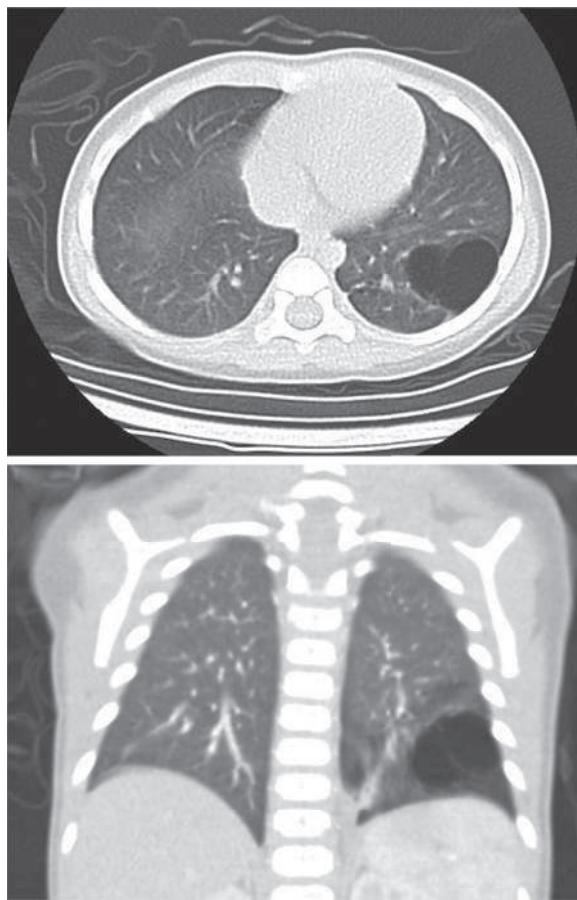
CT scans of CPAM in the left lower lobe of the lung. (From Wong KKY, Flake AW, Tibboel D, et al. Congenital pulmonary airway malformation: advances and controversies. *Lancet Child Adolesc*. 2018;2:290–296, Fig. 1.)
